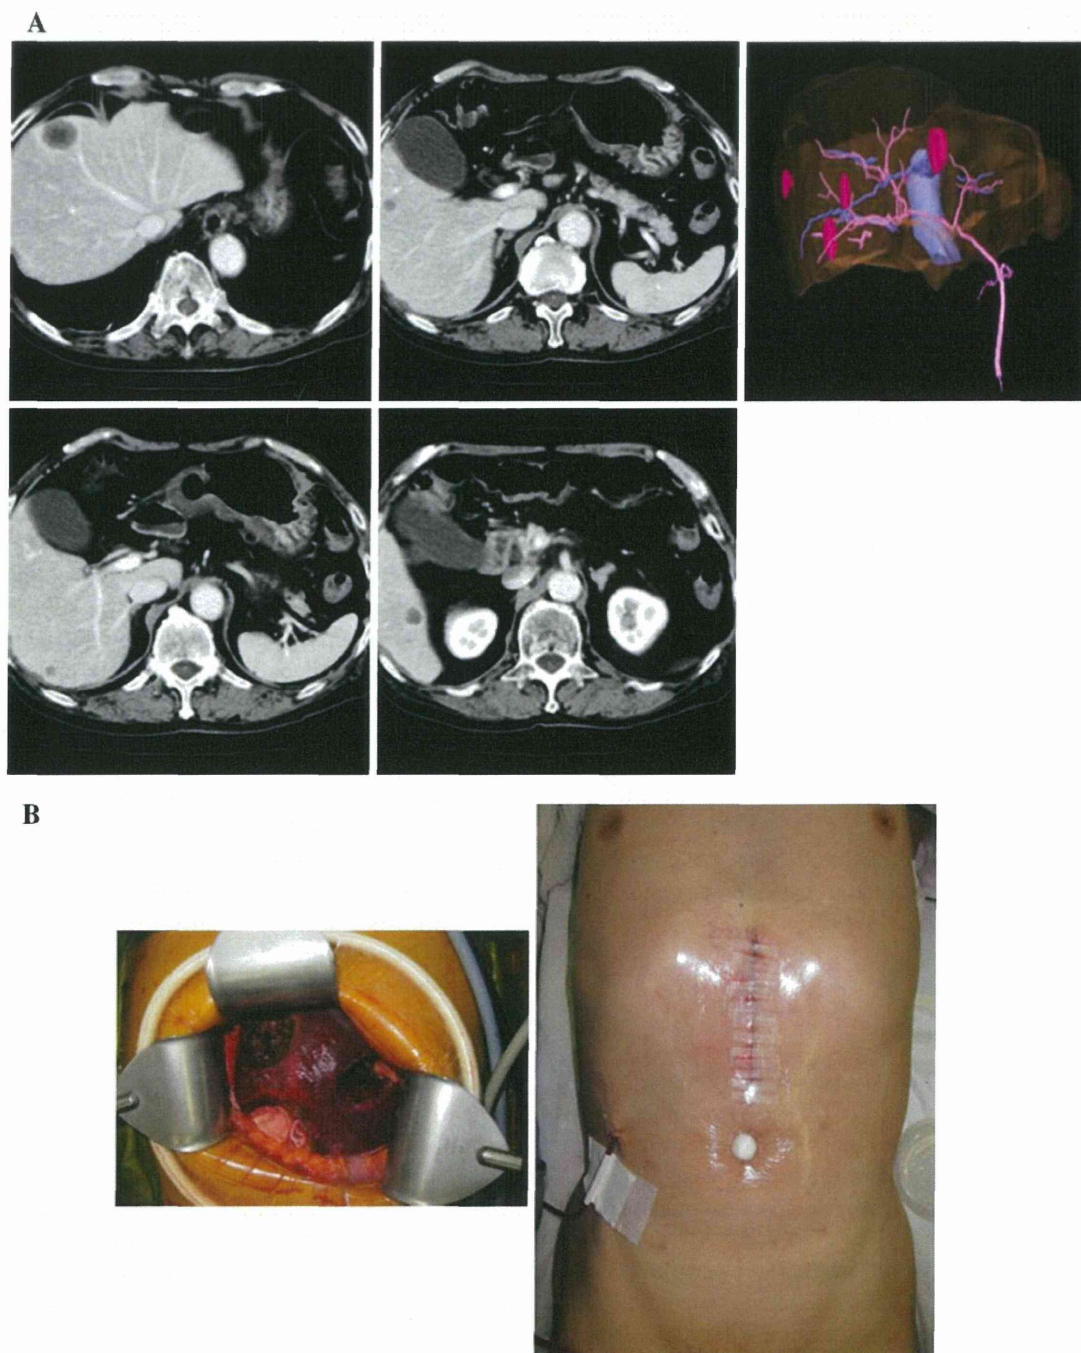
A CT images of multiple colorectal metastases treated by a hybrid method. The *right panel* is a 3D reconstructed image made from CT scans obtained by a Synapse Vincent instrument (Fujifilm Medical, Tokyo, Japan). B Local resection was performed for four
